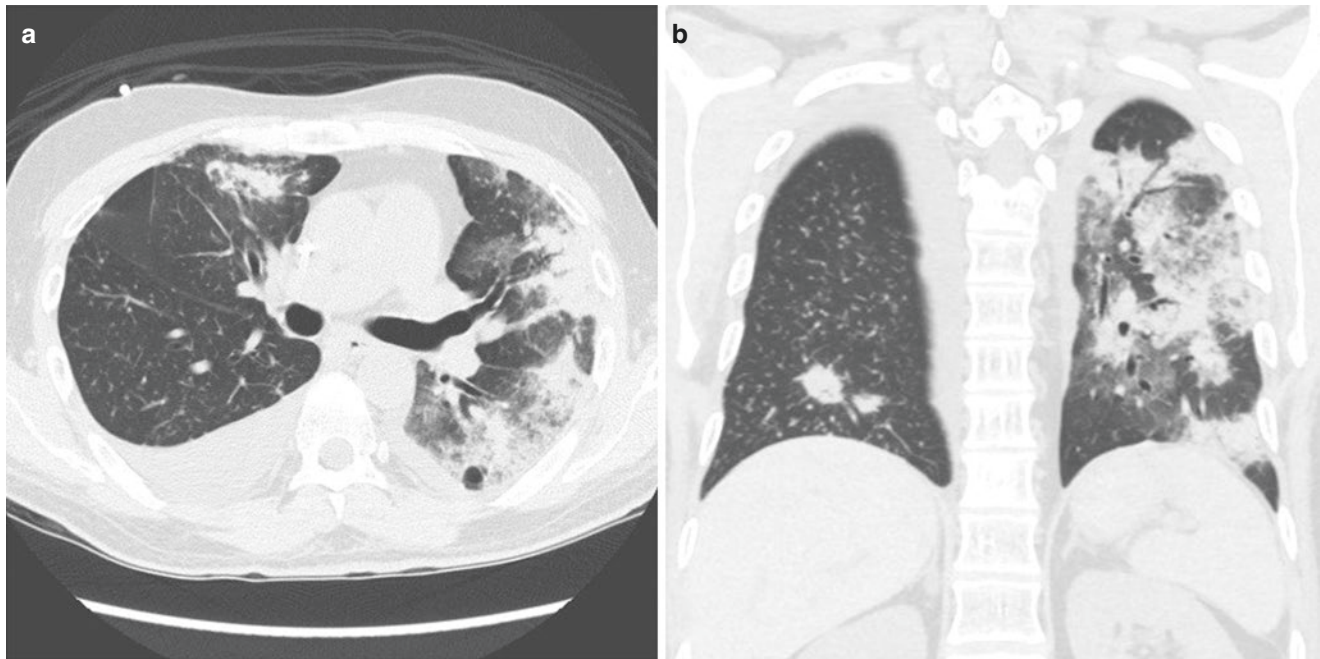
(a) Axial noncontrast-enhanced CT chest through the mid-lungs (lung windowing) demonstrates left greater than right peripheral areas of nodular consolidation and ground glass. (b) Coronal CT chest
